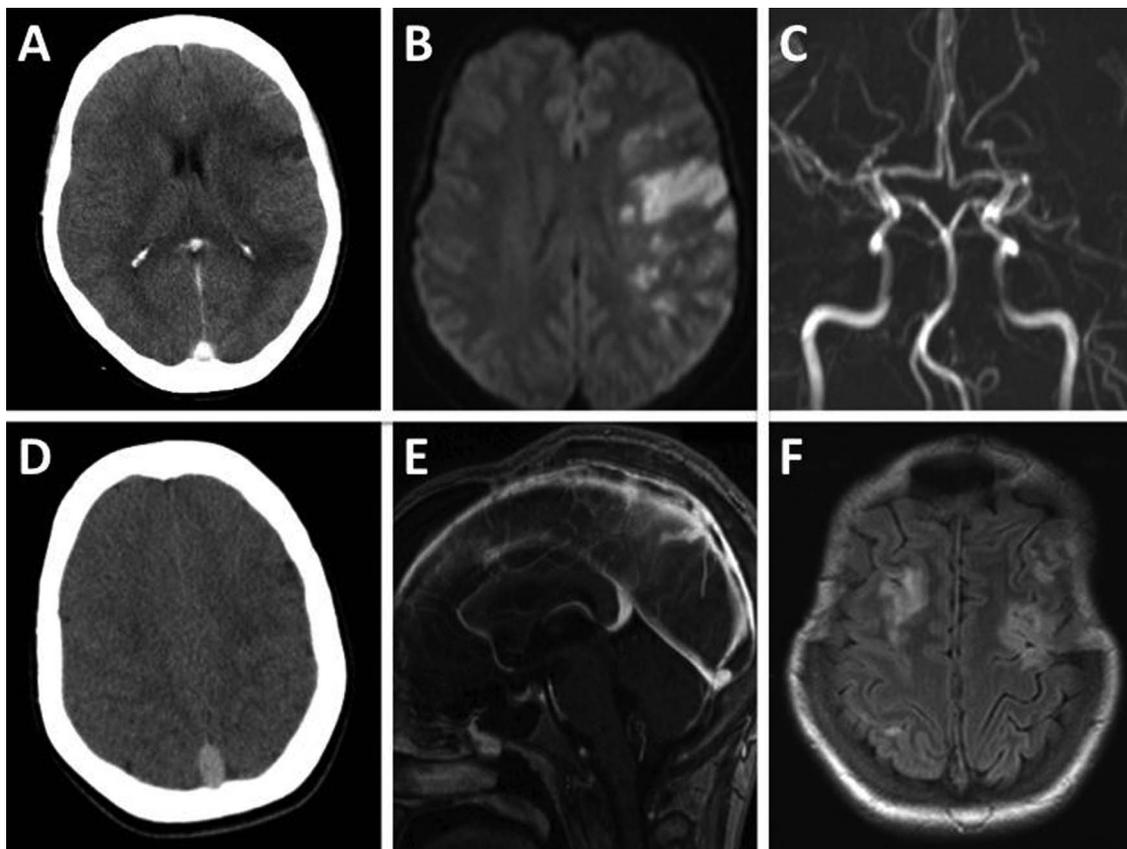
Non-contrast head CT showing frontal and parietal hypodensities. (A) Diffusion-weighted imaging showing areas of restricted diffusion on left middle cerebral artery (MCA) territory. (B) MRI showing an occlusion of the left MCA. (C) Non-contrast head CT with sagittal sinus hyperdensity, suggestive of venous thrombosis. (D) Venous MR angiography showing a superior sagittal sinus, thrombosis with a partial recanalisation (E) and fluid attenuated inversion recovery sequence demonstrating bilateral frontal hyperintensities suggestive of venous infarction and a bifrontal craniectomy (F).
